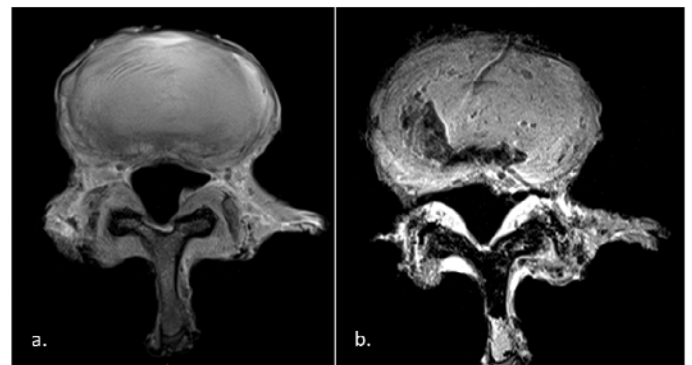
a.) Pre-test MRI (T1) axial image of sample FSU. b.) Post-test MRI (T1) axial image of the same FSU.
